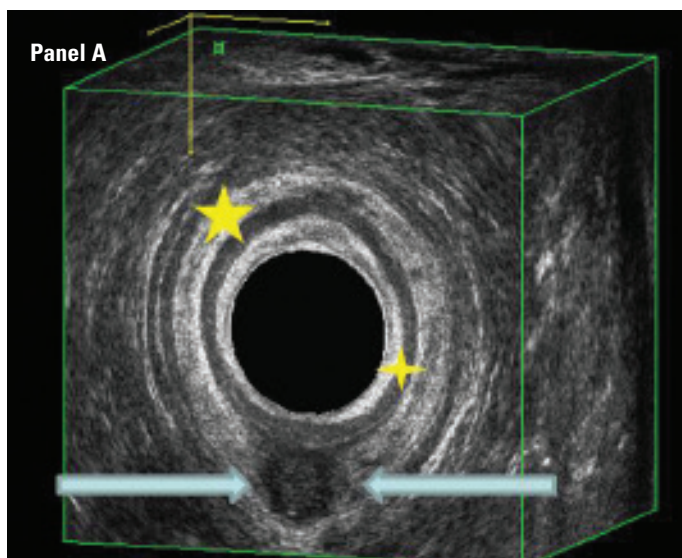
Trans rectal ultrasound examination with 3D reconstruction of an intersphincteric perianal fistula. Panel A: Transverse section with arrows pointing to fistula situated posteriorly at 6 o'clock. Large five-pointed star indicates external sphincter which is seen as an outer, echorich and somewhat thick ring. Smaller four-pointed star indicates internal sphincter which appears as an inner, echopoor and thin ring. Panel B: Demonstrates 3D reconstruction of perianal fistula showing its extent and direction from anal lumen towards skin surface.
